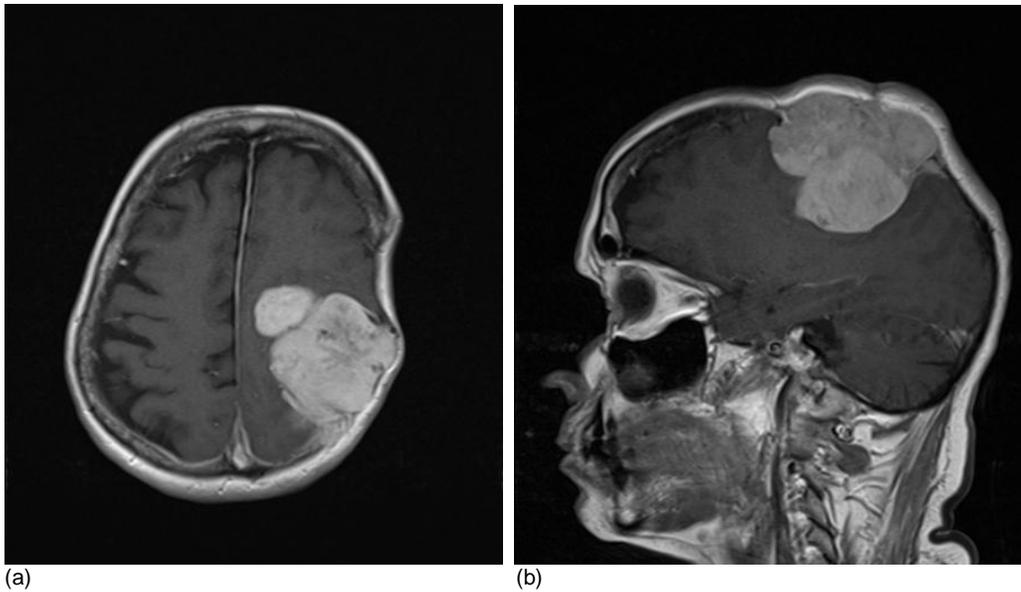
(a) Preoperative MRI brain contrast enhanced T1 weighted axial image showing a large extra axial lobulated left fronto-parietal mass lesion compression the brain parenchyma with resultant mass effect. (b) Preoperative MRI brain contrast enhanced T1 weighted sagittal image showing a large extra axial lobulated left fronto-parietal mass lesion compression the brain parenchyma with resultant mass effect along with involved overlying skin.
